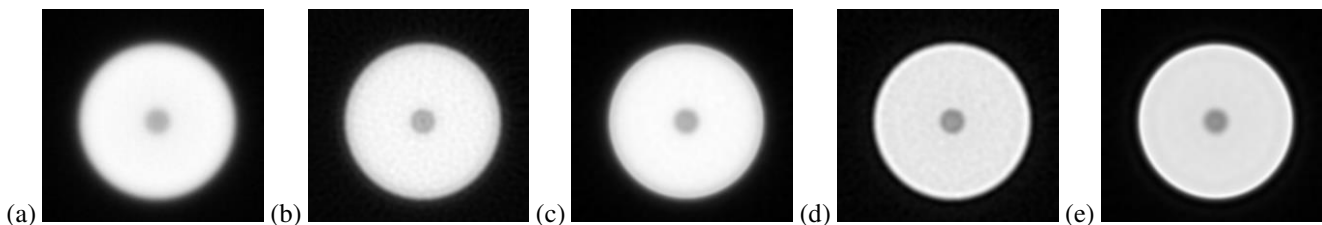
AM RQI cylinder slice of CT reconstructions (a) baseline no deconvolution, (b) FBP model with Wiener deconvolution, (c) FBP model with CGD, (d) IBD model with Wiener deconvolution, and (e) IBD model with CGD.
